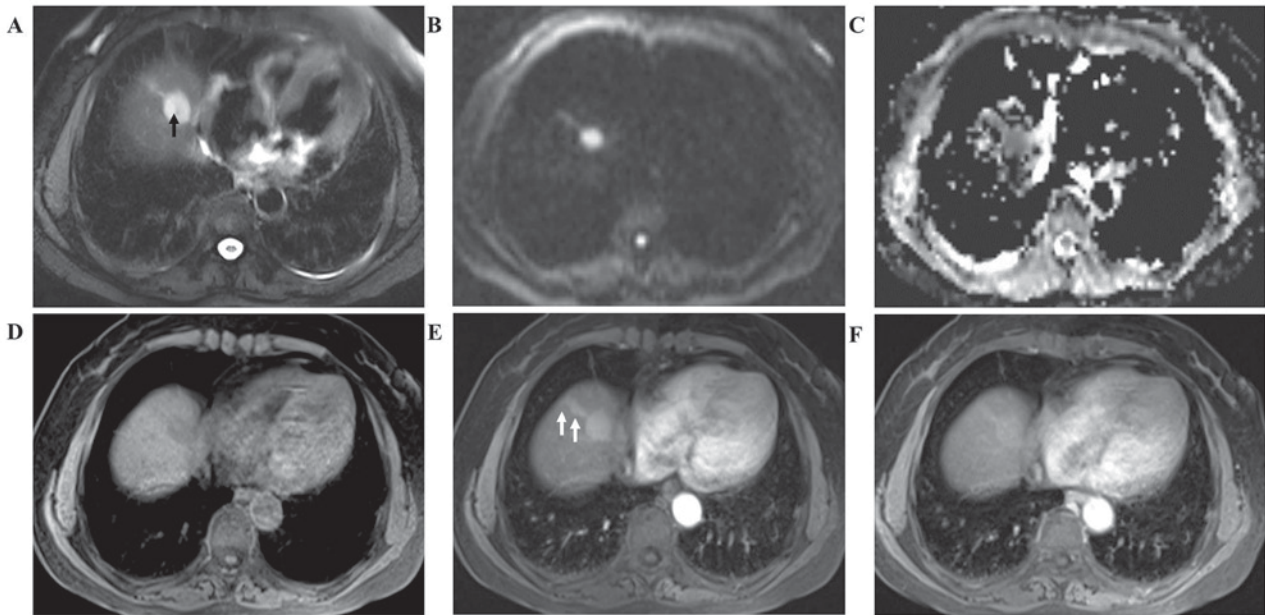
Magnetic resonance imaging (MRI) findings of the lesion. (A) T2-weighted imaging revealed a hypointense nodule with a calcification (arrow). (B) The nodule and the strip displayed diffusion restriction and hyperintensity on diffusion-weighted imaging and (C) a low apparent diffusion coefficient. MRI revealed (D) hypointensity, with (E) significant (arrows) and (F) persistent enhancement of the lesion following contrast administration.
